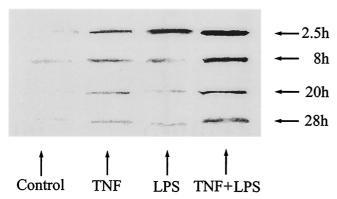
Time course of NF- κ B activation in HUVEC. Cells were harvested and processed at 2.5, 8, 20, and 28 h. The amount of NF- κ B in nuclear extracts was still upregulated at 28 h. Shown are scans of radiographic bands obtained with a Molecular Dynamics Densitometer (model 1.30) and ImageQuant Scanner software (version 3.3).
